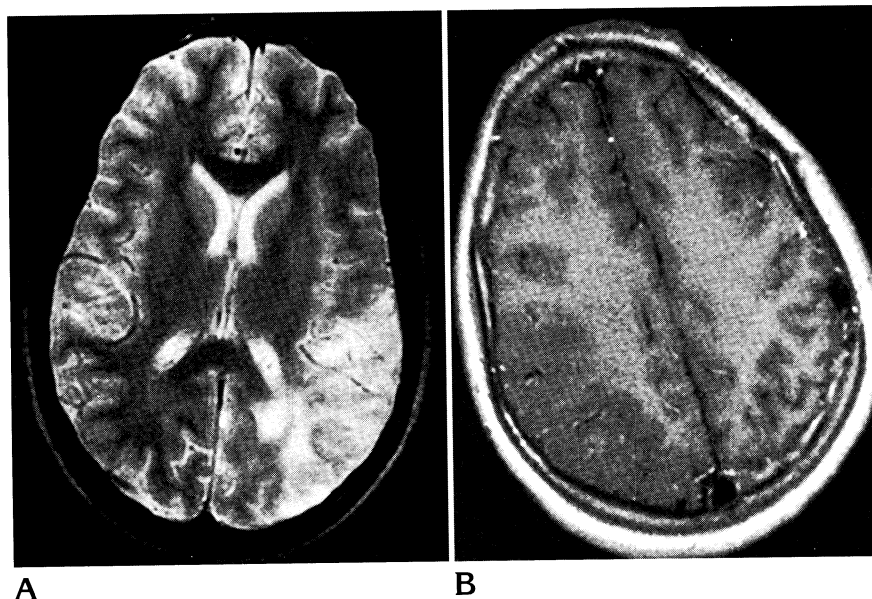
Case 3. A, MR axial T2-weighted image (3000/90/1) shows a left temporooccipital subacute infarction involving both gray and white matter.
